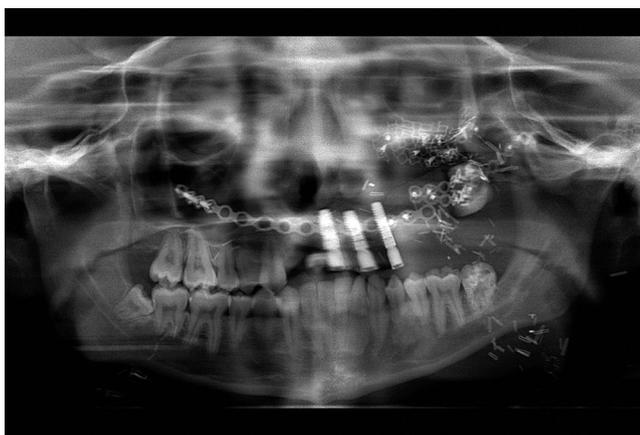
Postoperative panoramic radiograph after placement of dental implants.
